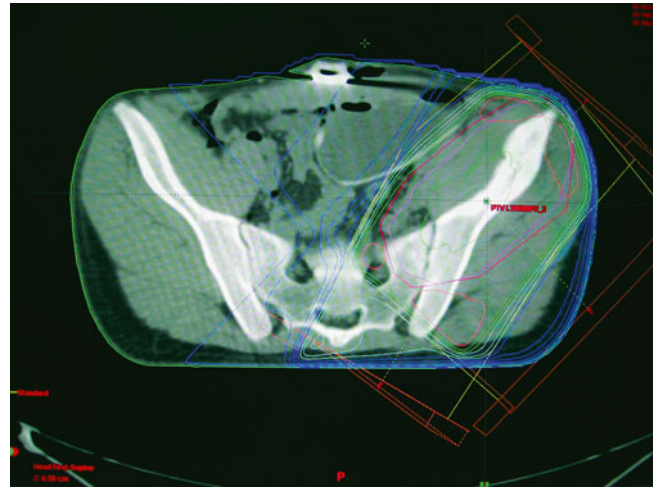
Pelvic CT scan showing spacer, target volume, beam arrangement and isodoses
